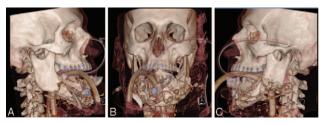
Three-dimensional computed tomography performed with arrival demonstrates the severely comminuted mandible from the right to the left angle. (A) Right lateral aspect. (B) Anterior aspect. (C) Left lateral aspect.
